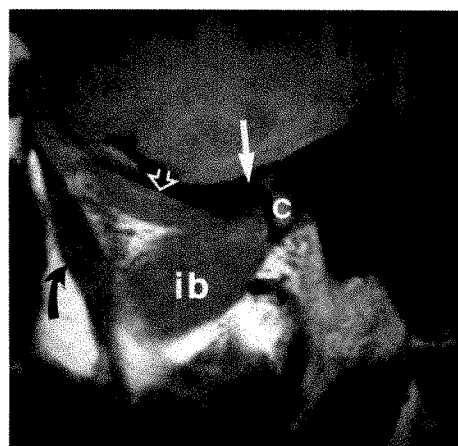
Normal pterygoid muscles with anterior displacement of TMJ meniscus. Closed-mouth sagittal MR image through medial pole of mandibular condyle (c) reveals anteromedial displacement of meniscus (*white arrow*) with normal pterygoid muscles. Open arrow = superior belly of right lateral pterygoid, ib = normal inferior belly of lateral pterygoid, curved arrow = normal medial pterygoid.
